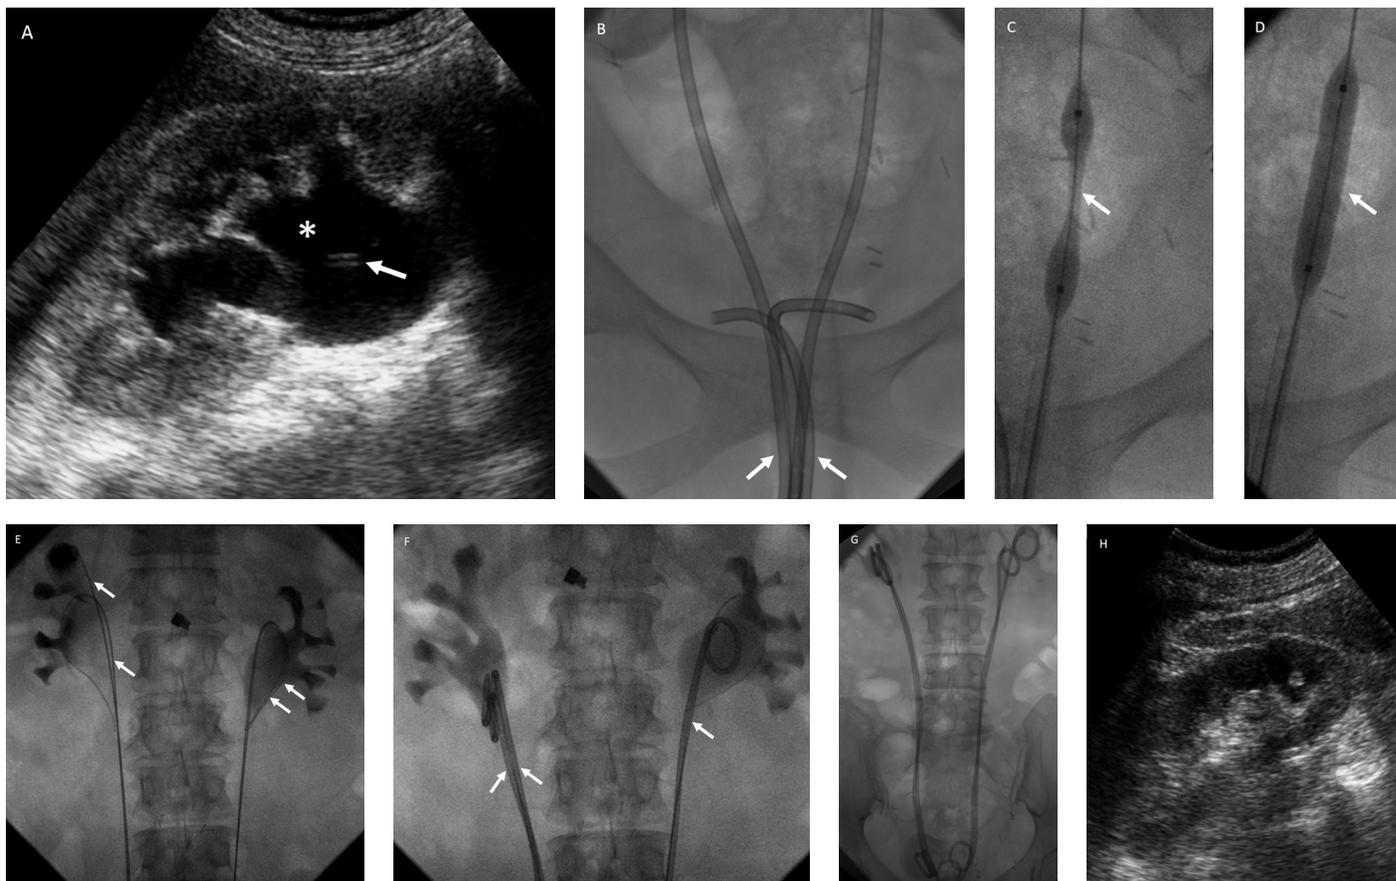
A 49-year-old woman with a previous history of cervix carcinoma underwent tandem ureteral stent (TUS) placement due to failure of indwelling single double-J stent (DJS). (a) Grayscale sonogram demonstrates presence of hydronephrosis (asterisk) due to non-functioning DJS (arrow). (b) First, the indwelling DJSs (arrows) were retrieved (retrograde fashion). (c, d) Prior to TUS placement, the ureteral strictures were dilated with balloon catheters (arrows). (e) Following balloon dilatation, bilateral guide wires (arrows) were guided into the renal pelvis. (f, g) Consequently, the ureteral stents were placed separately in retrograde fashion. (h) Grayscale sonogram obtained after the TUS placement reveals no hydronephrosis.
